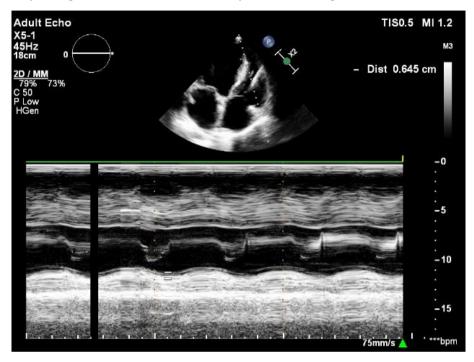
Resting Echocardiography
